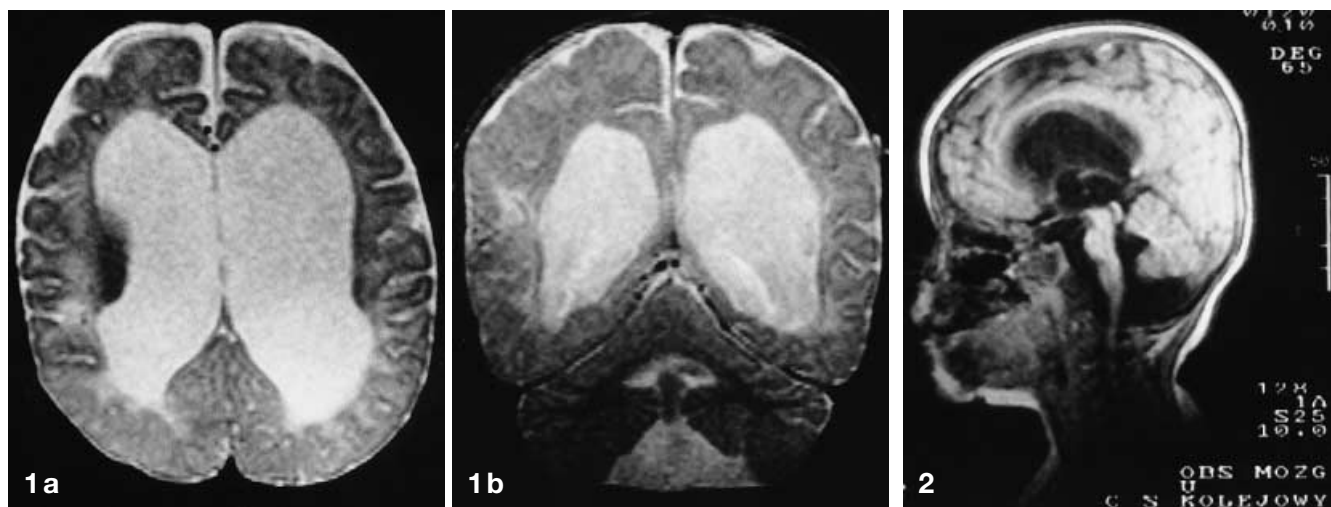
T2-weighted images a axial, b coronal: there is marked dilatation of the supratentorial ventricular system, with moderate cortical atrophy, delayed myelination of the cerebral white matter and foci of un- or demyelinated white matter in the parietal lobes
